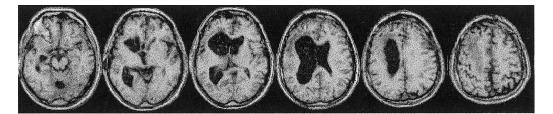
MRI scans (T1 weighted) from patient GP at the time of testing. This scan was normalized using the linear-alignment function from SPM software <www.fil.ion.bpmf.ac.uk/spm/>. These six slices correspond to Talairach and Tournoux [22] planes of -14, -2, 10, 22, 34, 46 mm, respectively.
